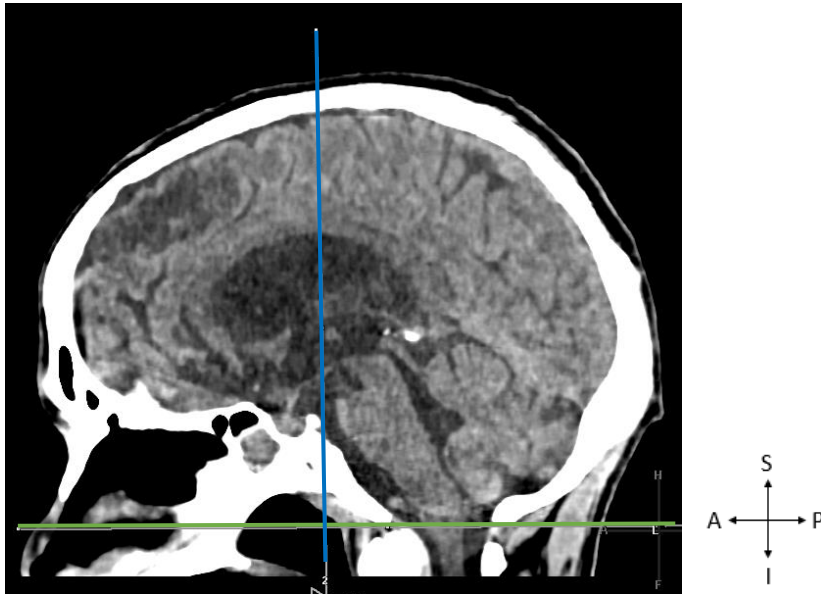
A CT scan showing the brain in the sagittal view indicating the reference line at the inferior border of the foramen magnum (green) and the reference line perpendicular to it (blue). Image taken from the GSH PACS (20 October 2023). S - Superior, A - Anterior, I - Inferior, P - Posterior.
